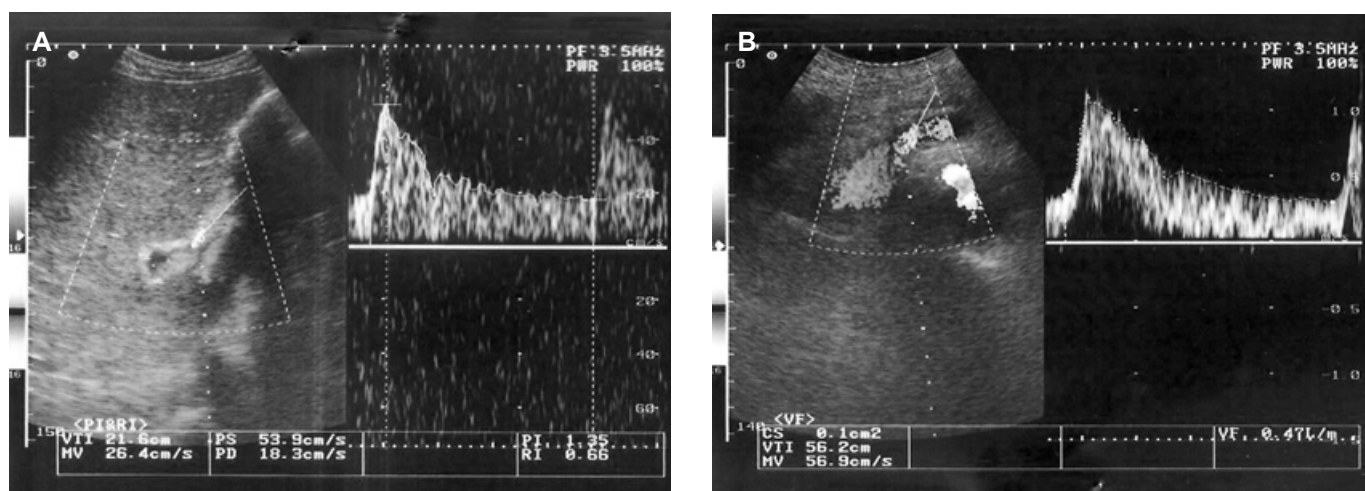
Doppler spectral waveform of hepatic artery in two different patients.
